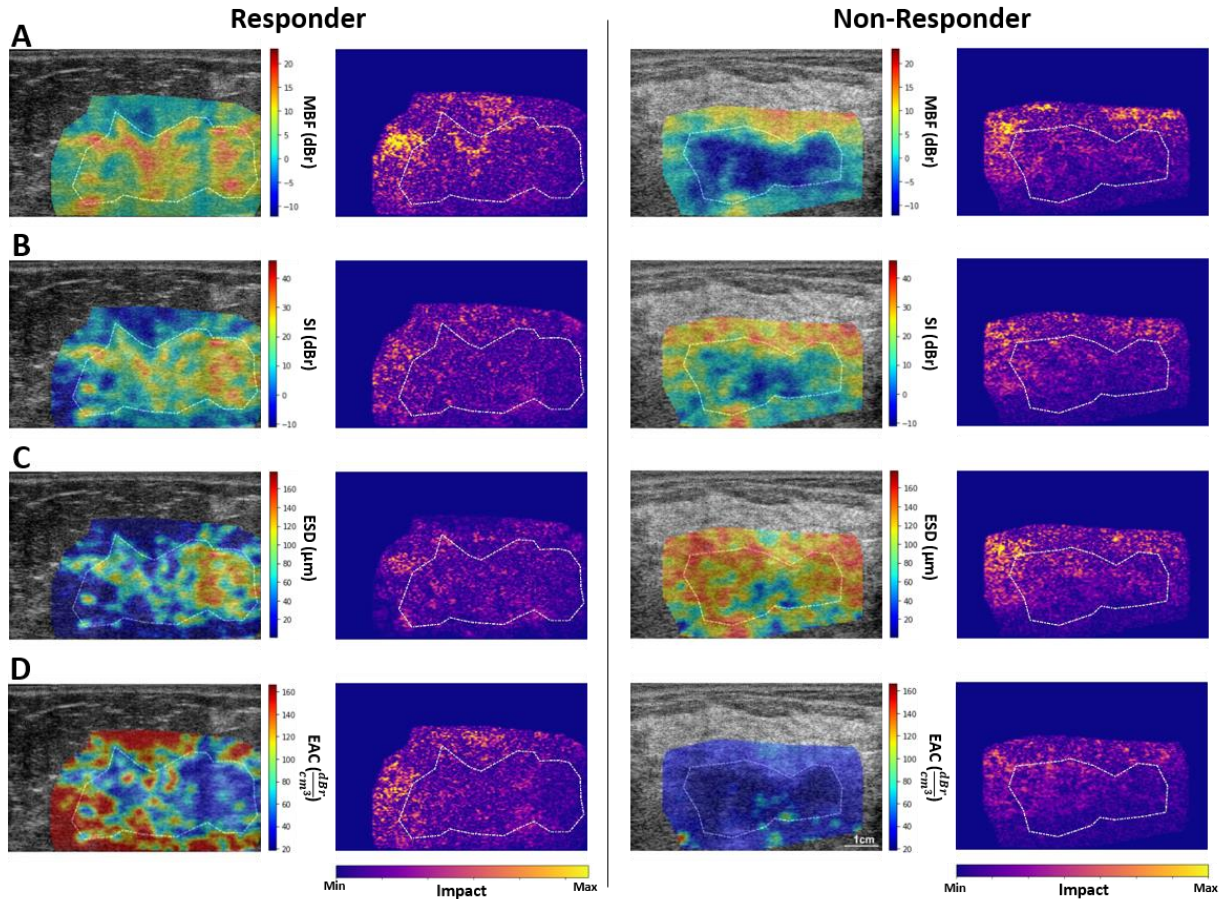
Ultrasound B-mode images with parametric overlays and of MBF (A), SI (B), ESD (C), and EAC (D) acquired at pre-treatment from a representative responder and non-responder to NAC, and the associated PDA maps visualizing the level of impact of different regions in each parametric image on the network’s decision (model 4 in Table 3.2). The tumor core has been outlined with white dashed line.
